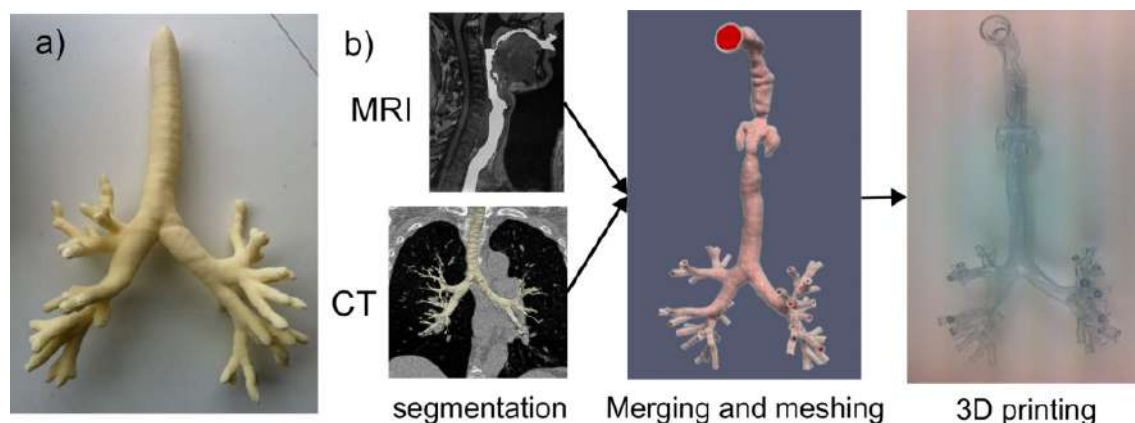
3D printed model of patient specific lung model used for velocity measurement with PC-MRI [96].
